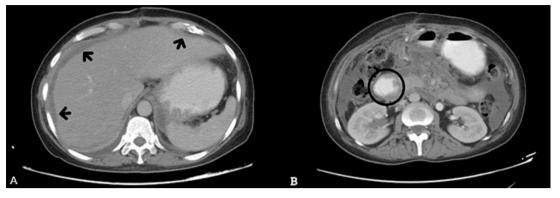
Postoperative computed tomography scan (CT)
